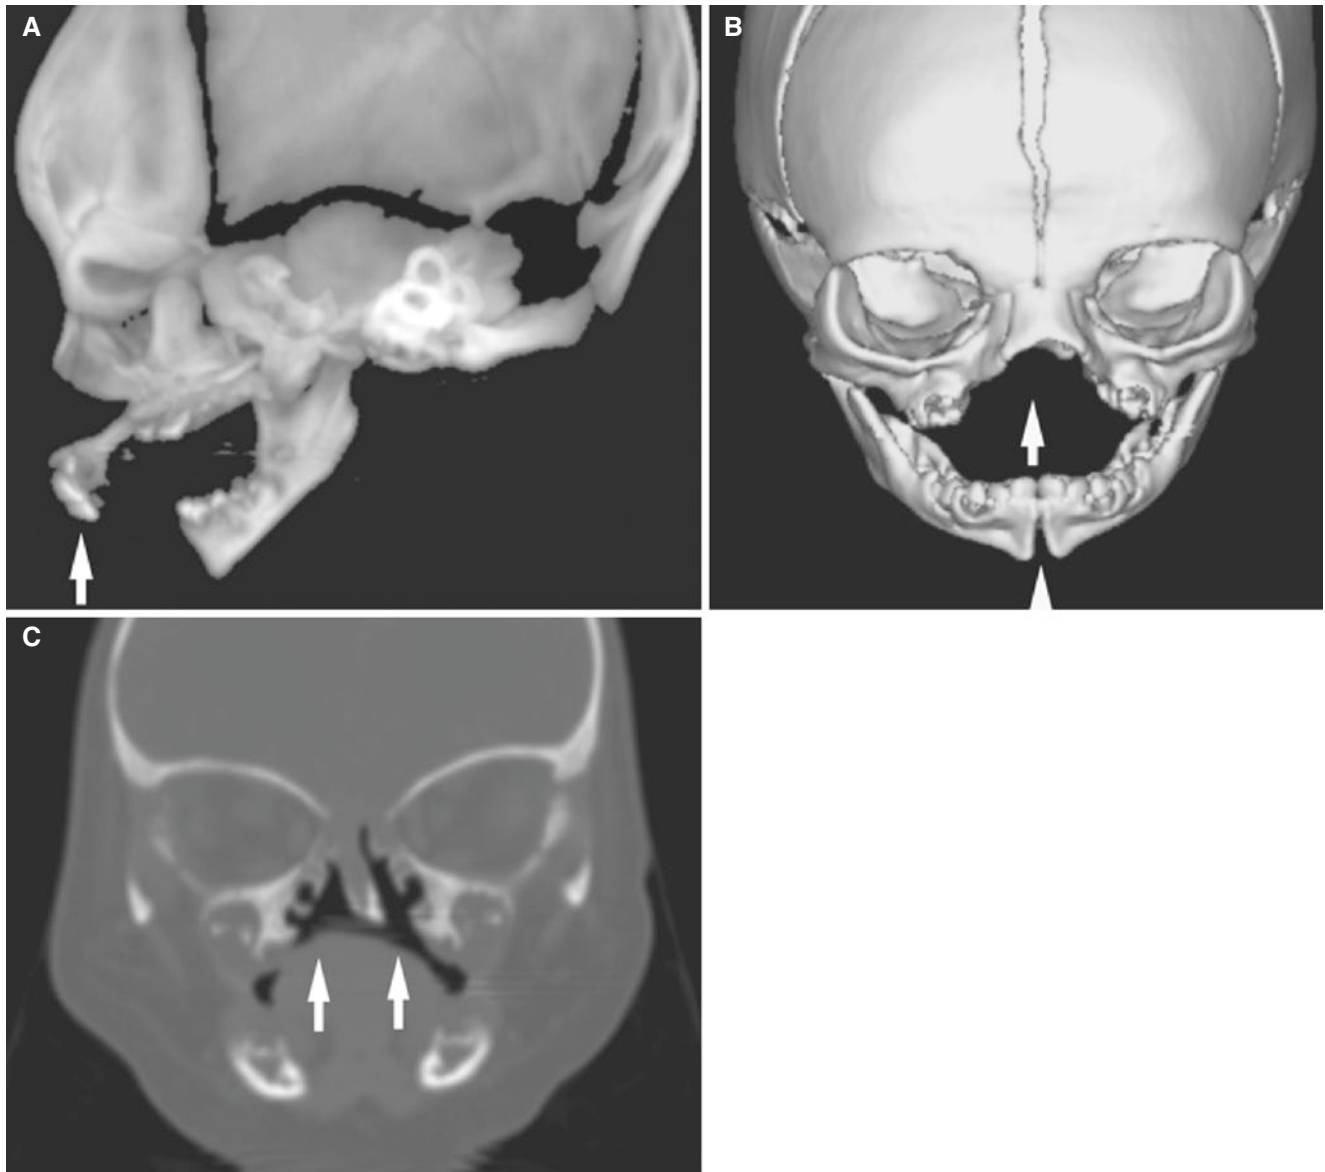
Cleft lip and palate, bilateral; 1-day-old male with multiple congenital anomalies (syndromic features). (A) Lateral CT scout image shows dislocation of premaxilla (*arrow*). (B) 3D CT image shows bilateral maxillary cleft (*arrow*) and mandibular midline cleft as well
